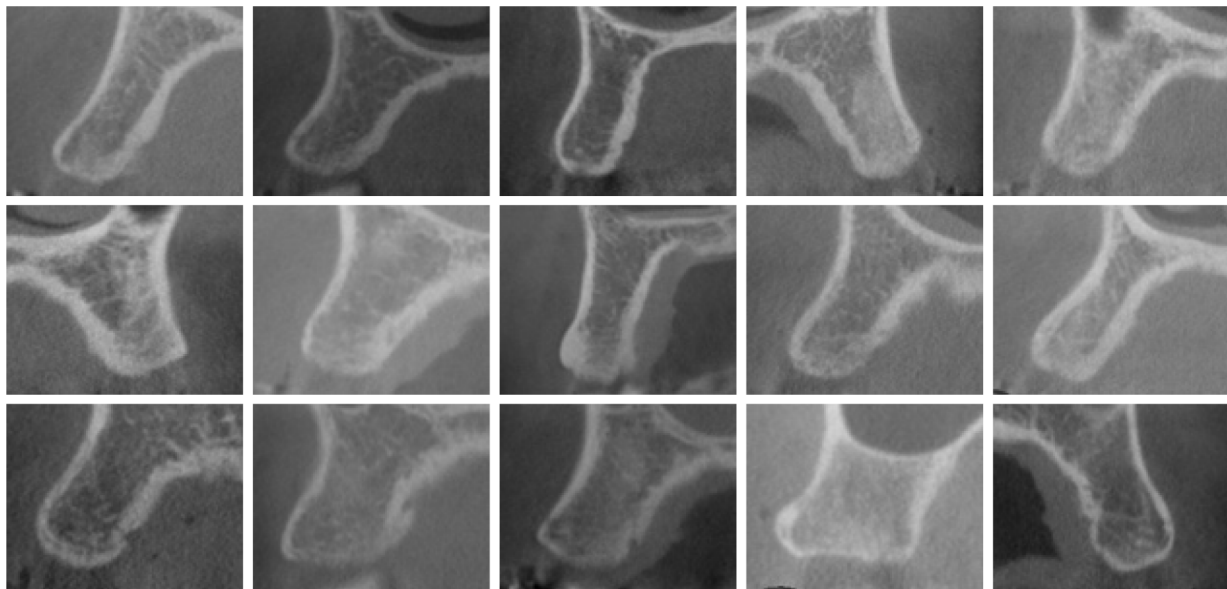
CBCT images for evaluation of alveolar bone density between maxillary second premolar and first molar from each participant.
